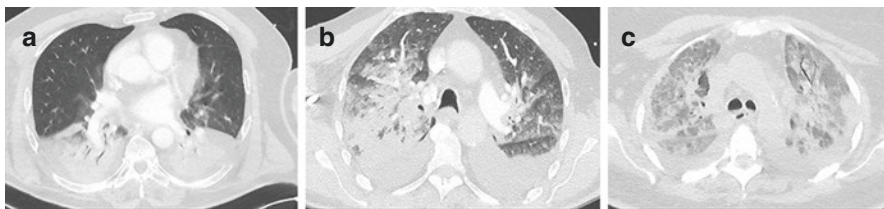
CT scan of three ARDS patients, Focal (a) and non-focal (b, c) with the same $\text{PaO}_2/\text{FiO}_2$ of 115 ± 3 mm Hg
